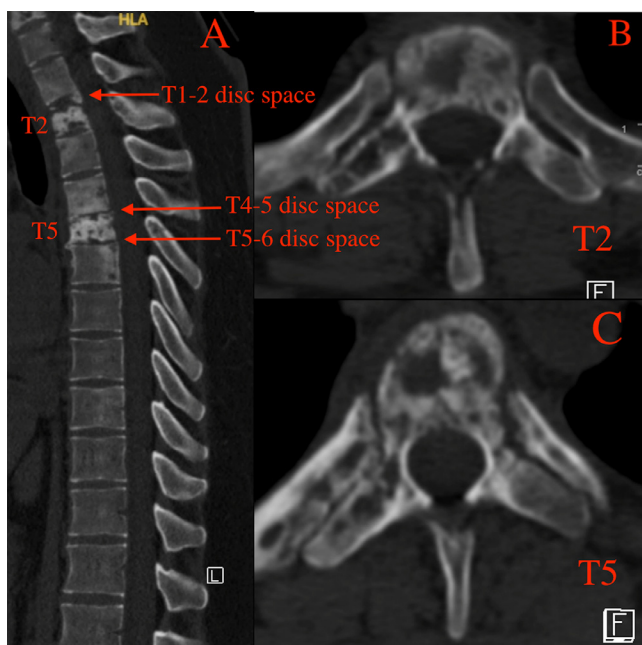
CT images of the thoracic spine. Panel A is a sagittal view that demonstrates bony destruction in multiple vertebral bodies and posterior ribs throughout the thoracic spine. Pathological fractures in the T2 and T5 vertebral bodies are demonstrated (T2 and T5 bodies labeled). Pathological involvement of the T1-2, T4-5 and T5-6 disc spaces can be seen (disc spaces labeled in red, denoted by arrows). Panels A and B are CT images in the axial view that represent pathological destruction of the T2 (B) and T5 (C) vertebral bodies and associated ribs.
